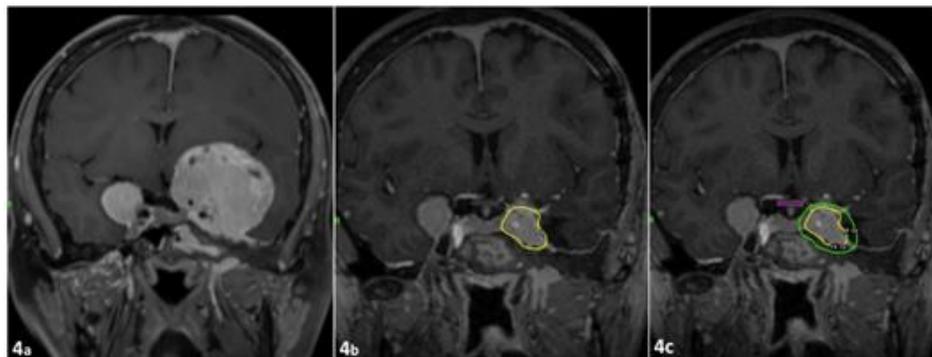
Example of a large clinoidal meningioma treated with combined approach, in a patient with bilateral clinoidal meningiomas. This 47 year-old female patient presented with visual loss on the left side. MR images showed bilateral anterior clinoid meningiomas (4a). On the left side, there was a large clinoidal meningioma markedly displacing the optic nerve and the chiasm and encasing the intradural carotid artery. There was also a component of the tumor in the cavernous sinus and in the sphenoid sinus extending laterally around the orbital apex. The intracranial part of the tumor was approached through a pterional craniotomy. The entire intradural part of the tumor was completely removed including the part encasing the carotid artery and its bifurcation. Following surgery, she completely recovered the vision on the left side. A second stage surgery was performed 3 months aiming at the extracranial part of the tumor, which was removed through an endoscopic endonasal approach. GKS for the cavernous sinus component was performed 6 months later. The tumor volume before surgery was 55.1 cc and the target volume at the time of radiosurgery was 1 cc. GKS was performed with a dose of 14 Gy at the 50% isodose (4b). The maximal dose to the optic chiasm and the left optic nerve was 3.6 Gy and 7.6 Gy respectively. Fig 3c shows the 8 Gy isodose line (as reference for the maximal dose allowed to the optic pathways) in green while the optic chiasm is delineated in pink showing its distance from the treated volume. The smaller tumor on the right side was completely excised through a suprabrow mini-craniotomy 3 months later.
